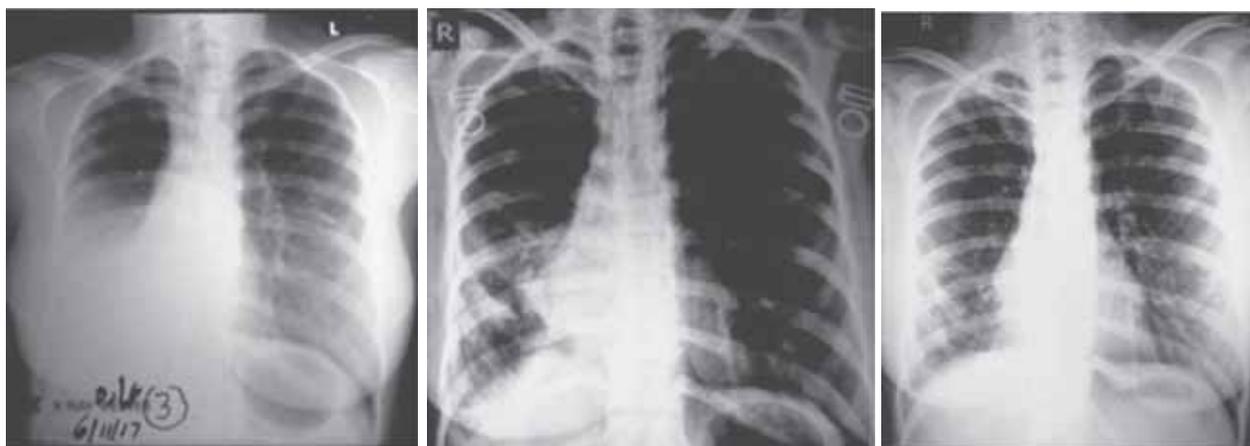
(a) Initial chest radiograph showing homogenous opacity in right middle and lower zones with ipsilateral shift of mediastinum and obliteration of right heart border and diaphragm (positive silhouette sign); (b) follow up chest radiograph at 3 weeks showing ill defined opacities in right lower zone and (c) at 3 months follow up having much visibility of aerated lung parenchyma.
